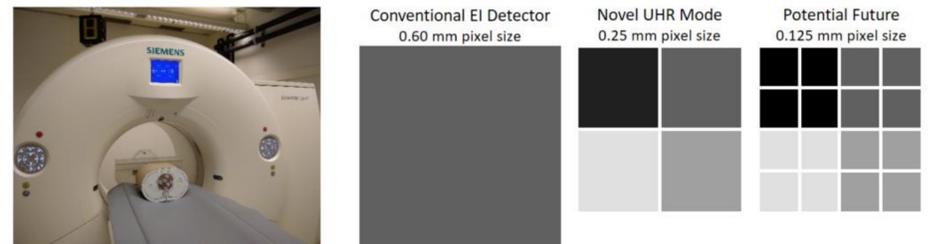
Left: Photograph of the prototype system. Right: Conventional CT detectors exhibit pixel sizes of about 0.6 mm (left). The novel photon-counting detector provides a pixel size of 0.25 mm (middle). These UHR pixels are actually binned from even smaller pixels with a size of 0.125 mm. Currently, only the 0.25 mm pixels are available due to data transfer rate limitations. However, future updates might allow measurements with a pixel size of down to 0.125 mm.
